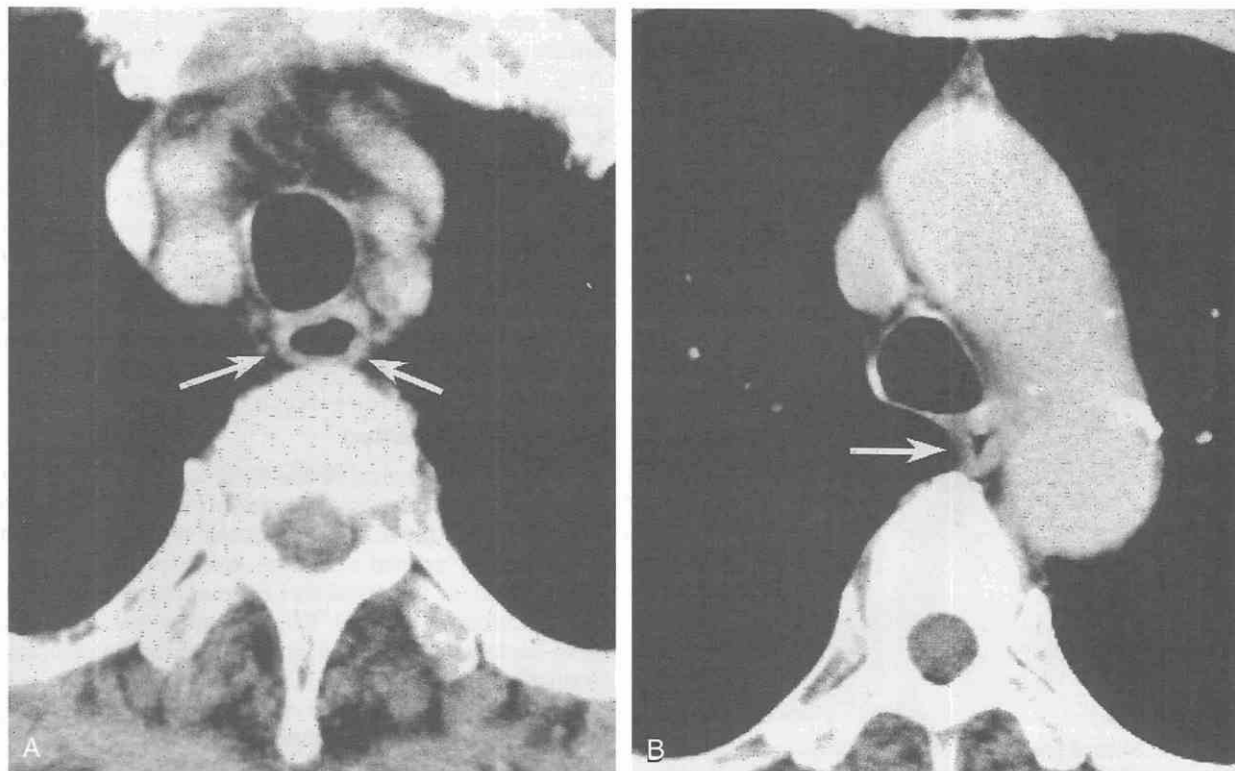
Normal esophagus. The cervical (A) and thoracic (B) segments (arrows) of normal esophagus appear as well-defined circular structures of soft tissue on this CT scan.
